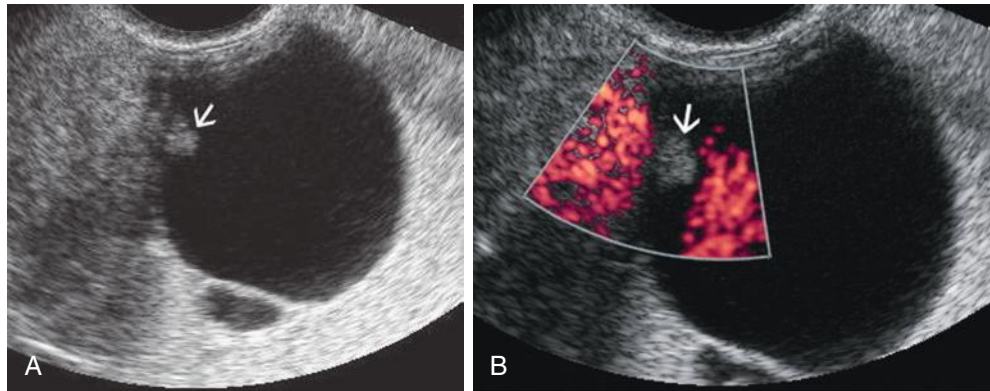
Serous cystadenofibroma. A, This predominantly cystic mass contains a small peripheral solid nodule (*arrow*). B, Power Doppler imaging shows no detectable flow in the small solid nodule (*arrow*). Color pixels in the anechoic fluid of the cystic mass are due to motion artifact.
